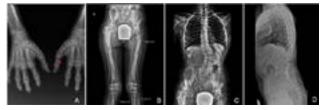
A - Hand radiography showing periarticular osteopenia, epiphyseal enlargement, particularly on the radius, and widened metaphysis of metacarpals and phalanges, with surface irregularities; B - Lower limb radiography showing flattening of the femoral head and dysmetria, as well as periarticular osteopenia and valgus knee; C, D - Spine radiograph showing platyspondyly (flattening of some vertebral bodies) and severe scolioses with right lumbar curvature.
